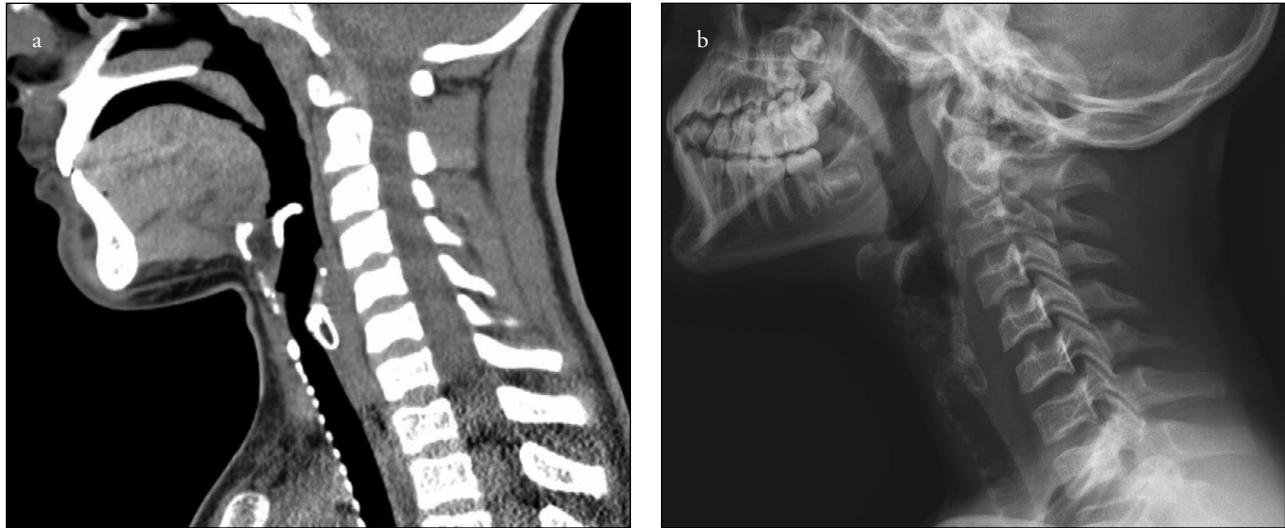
a, b. MR imaging and cervical spine radiographs of the patient
